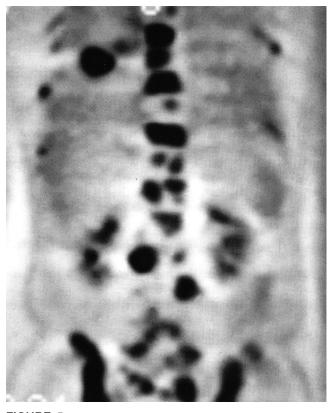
Coronal PET image 1.5-cm thick through the midpelvic region and thoracic spine. The image was acquired 1 hr after giving 10 mCi of ¹⁸F-FDG to a patient with small-cell lung cancer. Note the intense FDG accumulation in tumored marrow (^{99m}Tcphosphate bone scan was normal) and in diseased lymph nodes. The primary lung lesion is seen in the upper left. There is FDG activity in the kidneys, the normal route of excretion.
